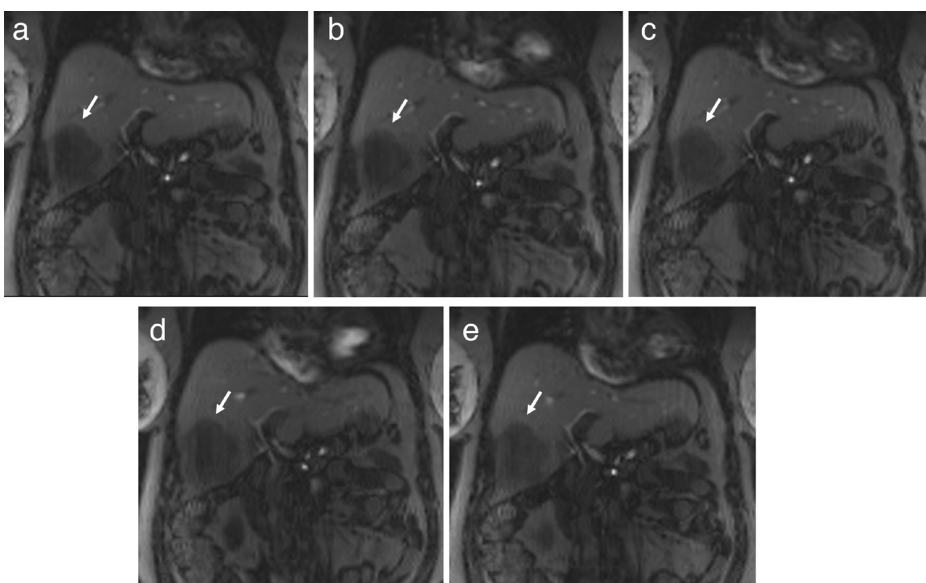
Measurement series 2. Real-time T1-weighted gradient-recalled echo sequences showing coronal planes with different repetition times of 5.47, 6.25, 7.03, 7.81, and 8.59 ms (a-e). Note the absence of difference in the conspicuity of hypointense target lesion (arrows) and vascular structures and the similar extent of artifacts.
